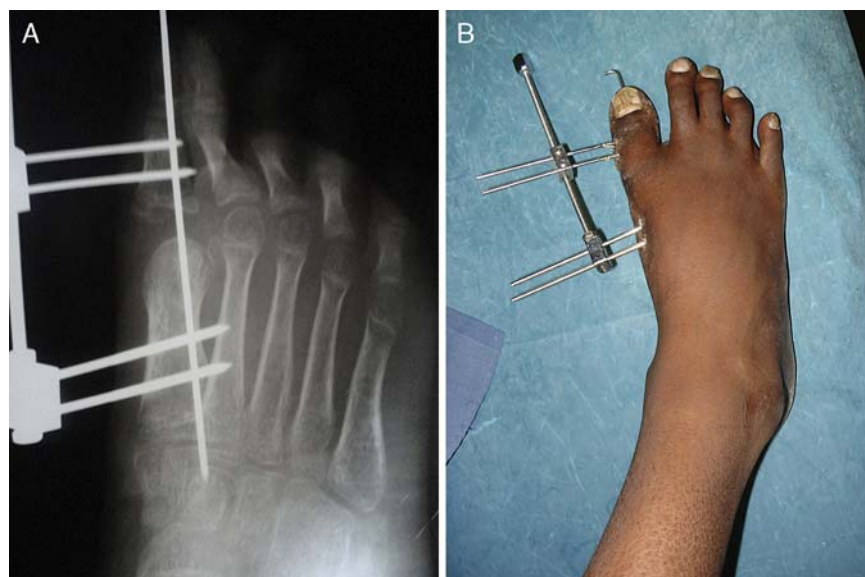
Follow-up radiographs (A) at 4 weeks and (B) at 6 weeks showing gradual distraction at the first metatarsophalangeal (MP) joint relocating the distal phalanx on the metatarsal head.
